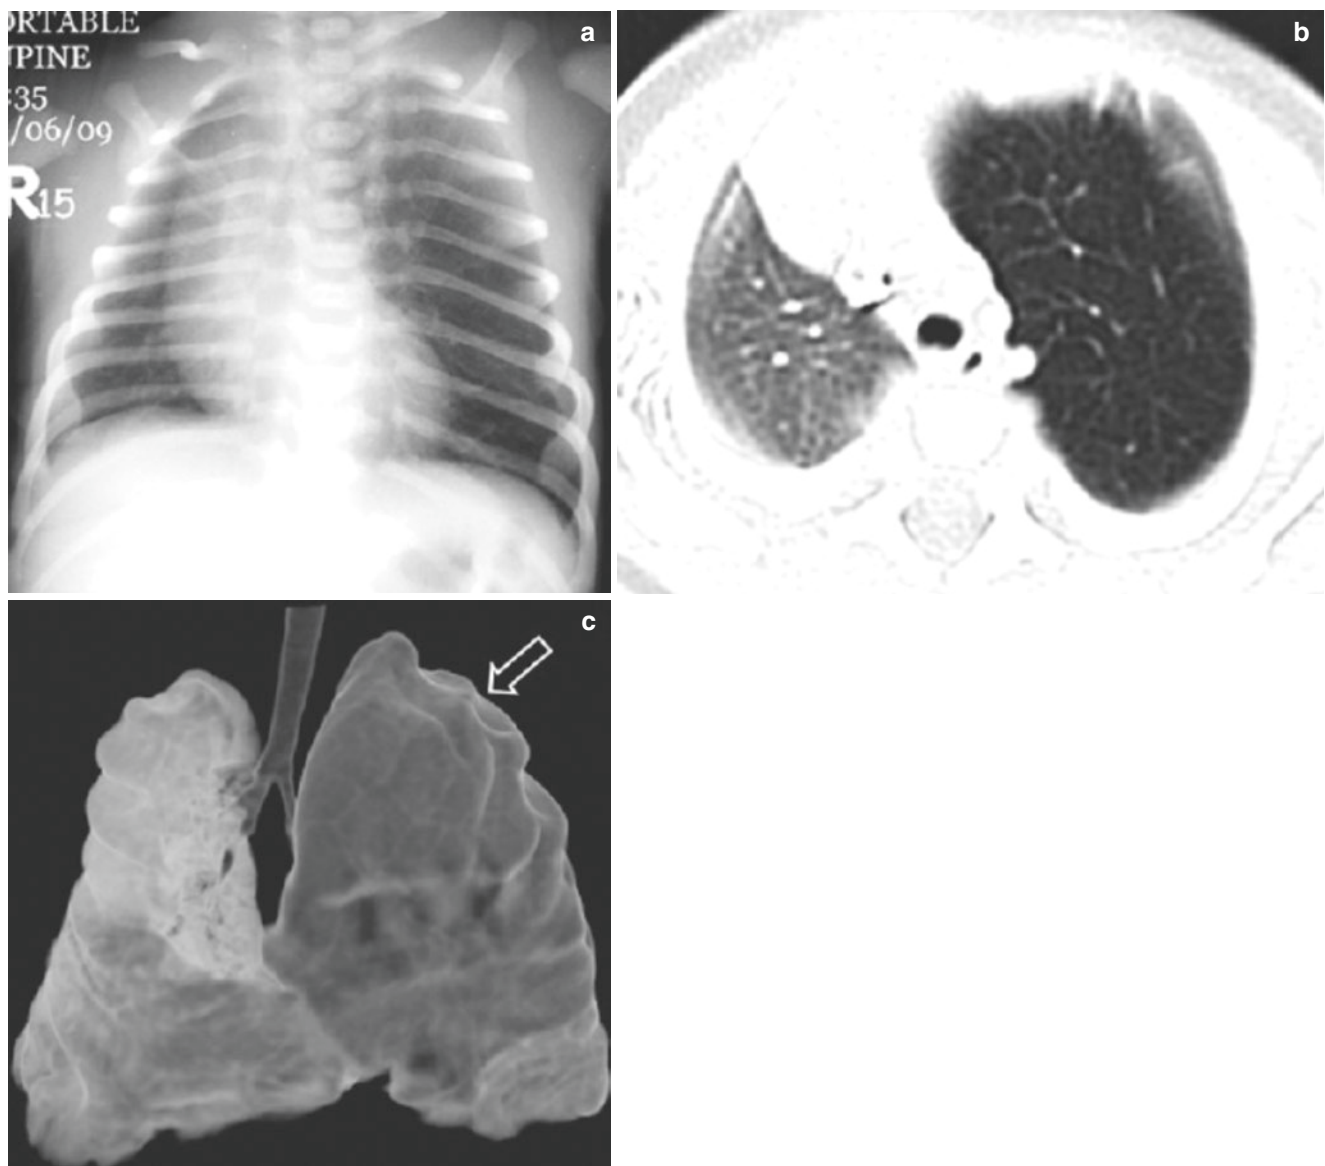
A 3-day-old boy presented with respiratory distress. Surgical pathology was consistent with congenital lobar emphysema. (a) Frontal chest radiograph shows increased lucency and hyperinflation of the left upper lobe. Also noted is mass effect upon mediastinum. (b) Axial lung
